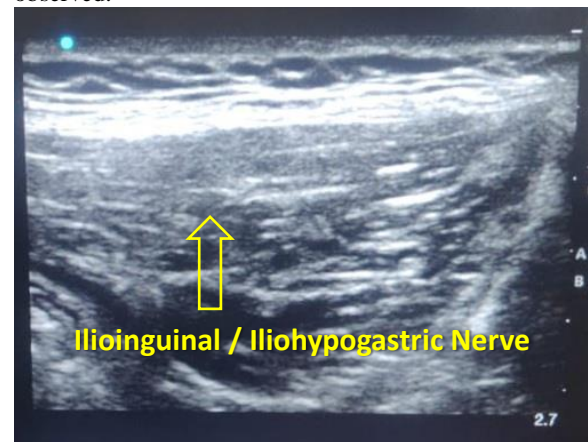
Image showing ultrasound guided IIIH nerve block
